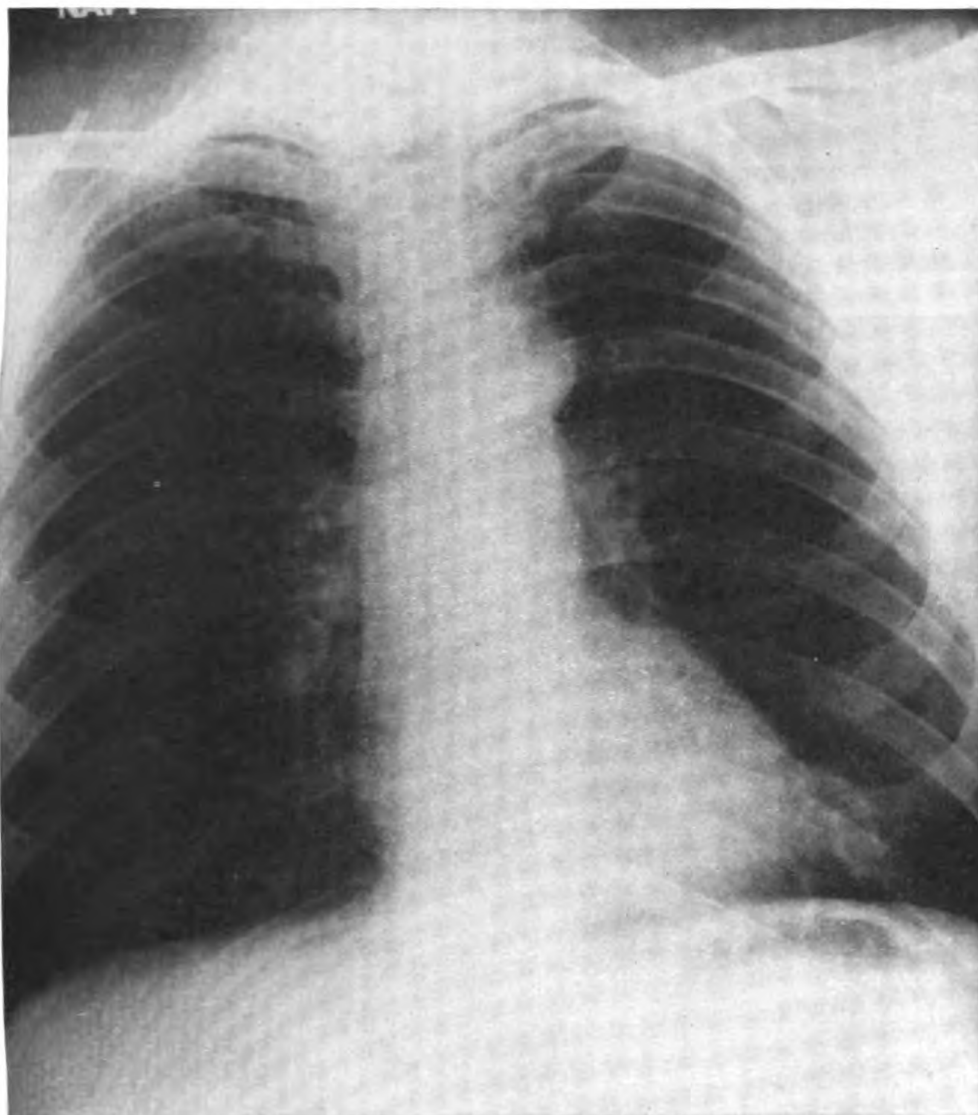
(June 1945) Roentgenogram indicating moderate obliteration of left costophrenic angle. Thickened, hazy, left inferior bronchovesicular markings with confluent density. Left subapical markings reveal increased bronchial drainage. (Note several concurrent old fractured ribs with moderate callus formation.)
